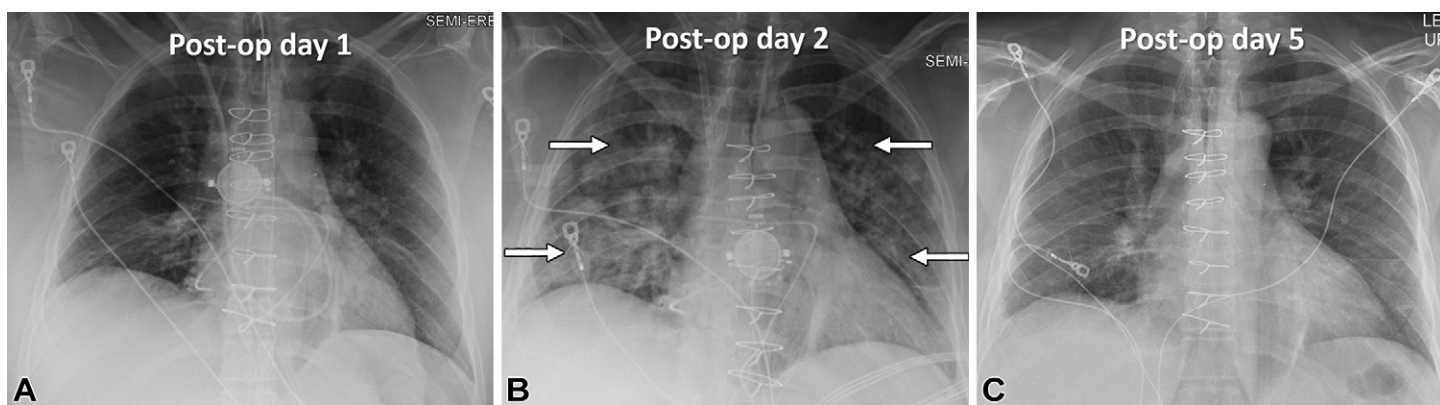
Reperfusion edema in a 36-year-old woman with CTEPH after PTE. (A) Chest radiograph 1 day after PTE shows mild bilateral perihilar opacity, likely reflecting mild pulmonary edema and potentially related to reperfusion edema or fluid overload. (B) Chest radiograph 1 day later shows markedly increased perihilar opacity (arrows), which is asymmetrically greater on the right and corresponded to the asymmetric distribution of thromboembolic disease in this patient. This is more suggestive of reperfusion edema, although alternative causes such as hemorrhage or infection would be difficult to entirely distinguish. (C) Chest radiograph on day 5 shows that the perihilar opacities have essentially resolved. The rapid resolution is compatible with reperfusion edema.
